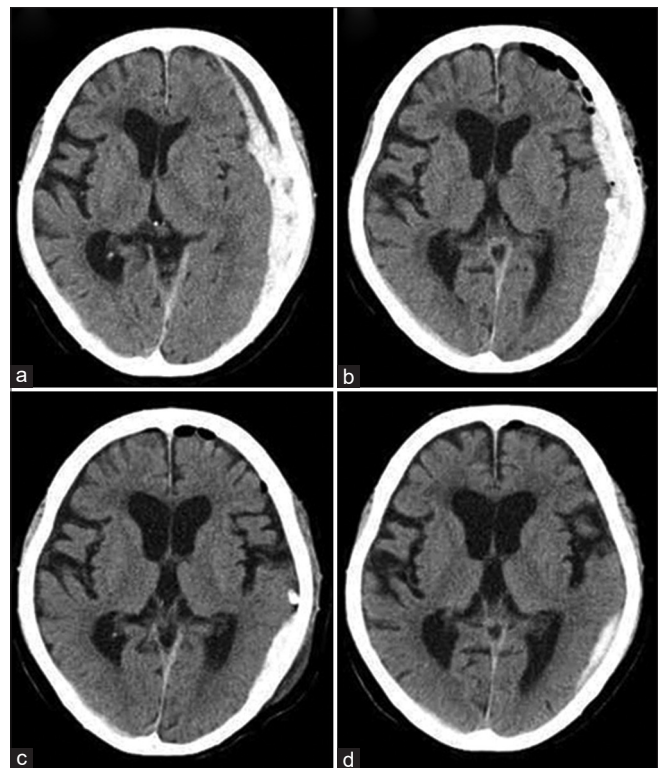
Computed tomography (CT) in a typical case of burr hole surgery (a) on arrival (day 0), (b) after the operation (day 1), (c) after drainage using urokinase (day 3), and (d) follow-up (day 8).
